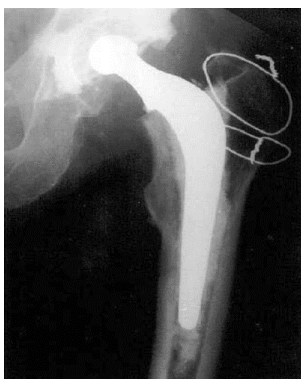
Radiograph of a Thompson's Prosthesis.
